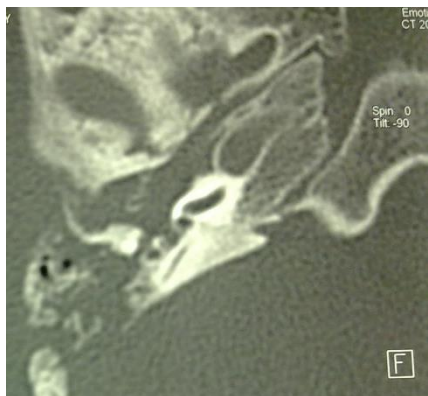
Otomastoiditis secondary to tuberculosis; Mastoidian CT Scan showing a filling of the tympanic cavity with osteolysis of the mastoid
